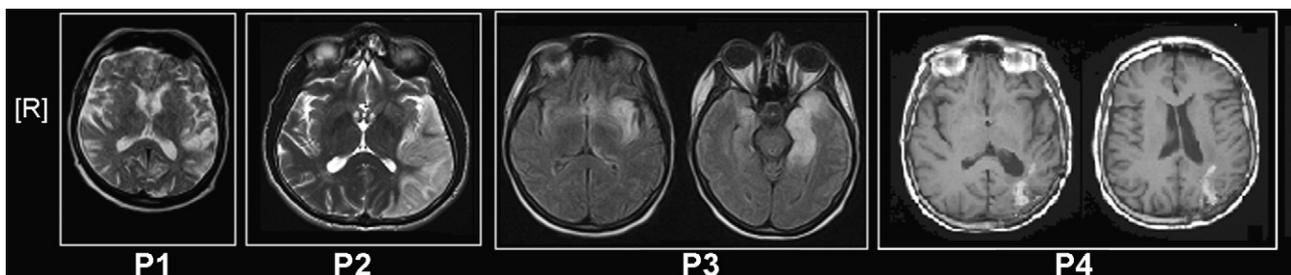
Site of lesion of each patient (MRI). Detailed descriptions are provided in the text.
